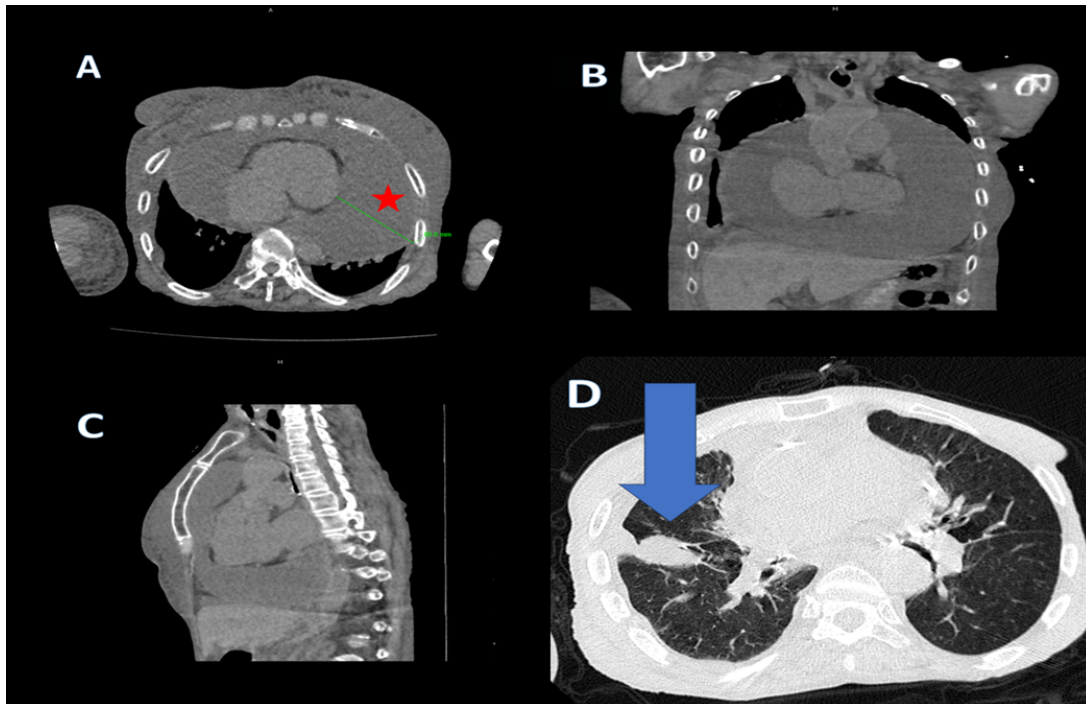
Radiologic evaluation of the giant pericardial effusion and the suspected primary pulmonary malignancy. (A) Axial non-contrast thoracic computed tomography (CT) soft-tissue window demonstrating a massive, circumferential pericardial effusion with a maximum depth of 82.0 mm (green line) compressing the cardiac chambers. (B) Coronal and (C) sagittal reformatted CT images highlighting the extreme distension of the pericardial sac and the resultant mass effect within the mediastinum. (D) Axial high-resolution CT (HRCT) lung window revealing a highly suspicious, irregular solid mass in the right lung (arrow), highlighting the diagnostic dilemma of an occult malignancy despite repeated negative pericardial fluid cytology.
